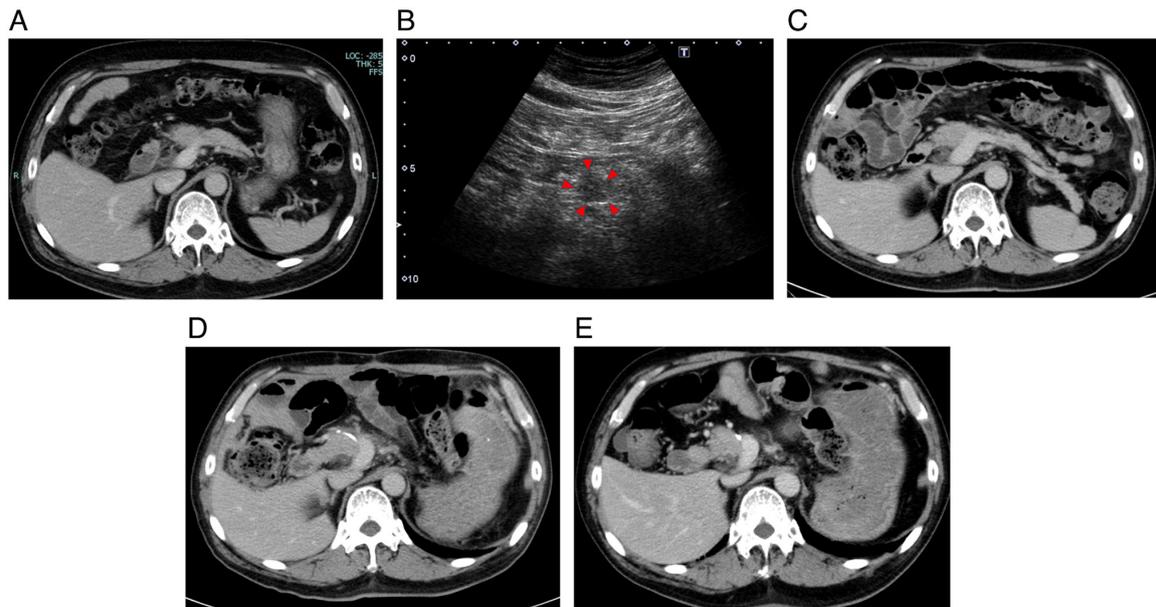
Imaging findings. (A) Abdominal CT before preoperative chemotherapy. The mass was obscure. (B) Abdominal ultrasound before preoperative chemotherapy: A 16.3-mm hypoechoic mass was identified in the pancreatic body (surrounded by red arrowheads). (C) Abdominal CT before CS: No new lesions were observed. (D) Abdominal CT after CS: No abnormal findings. (E) Abdominal CT 7 years after CS. No new lesions were observed. CS, conversion surgery; CT, computed tomography.
